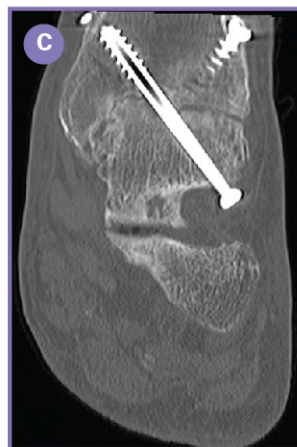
Pre-operative weightbearing radiographs demonstrating nonunion following prior attempted lateral approach ankle fusion with fibular takedown from outside institution (A) AP and (B) Lateral. CT scan imaging confirming nonunion of initial ankle fusion attempt (C) Coronal and (D) Sagittal.
